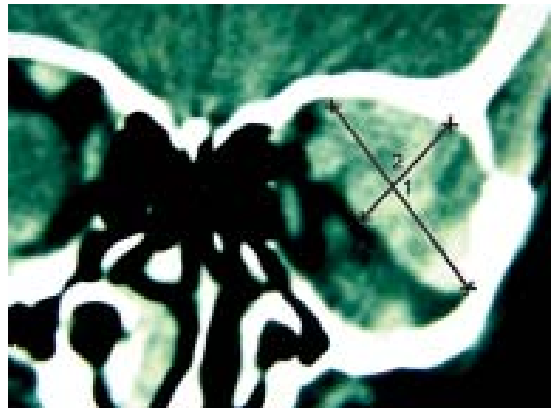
CT of the orbit showing a mass occupying the superotemporal part of the orbit (Courtesy: Dr MS Bajaj, Dr RP Centre, New Delhi)
